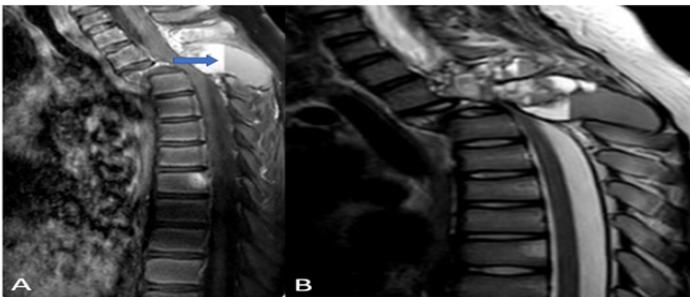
MRI showing large posterior vertebral mass characterized by fluid-fluid level (arrow) at spinal level T1-T3, vertebral collapse at T2 and spinal cord compression; (A) sagittal T1-weighted contrast-enhanced MRI, (B) sagittal T2-weighted MRI.
